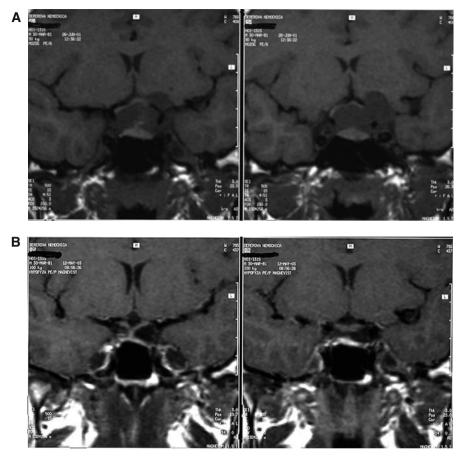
Coronal MRI scans of suprasellar extraventricular craniopharyngioma encapsulating the bifurcation of the internal carotid artery before (A) and after (B) radical tumor removal
